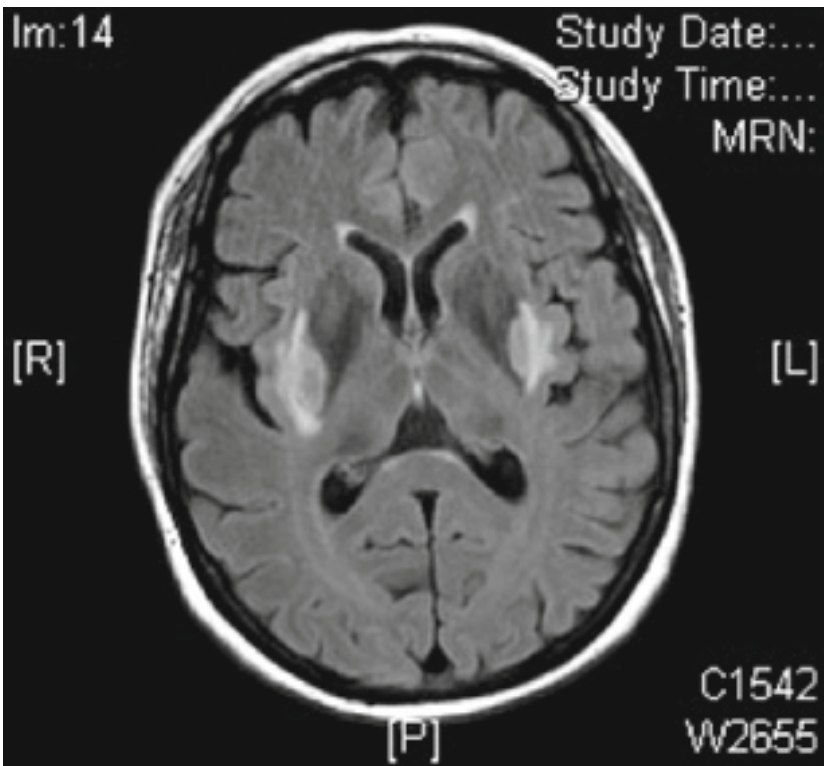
MRI: bilateral putaminal hyperintensity.
